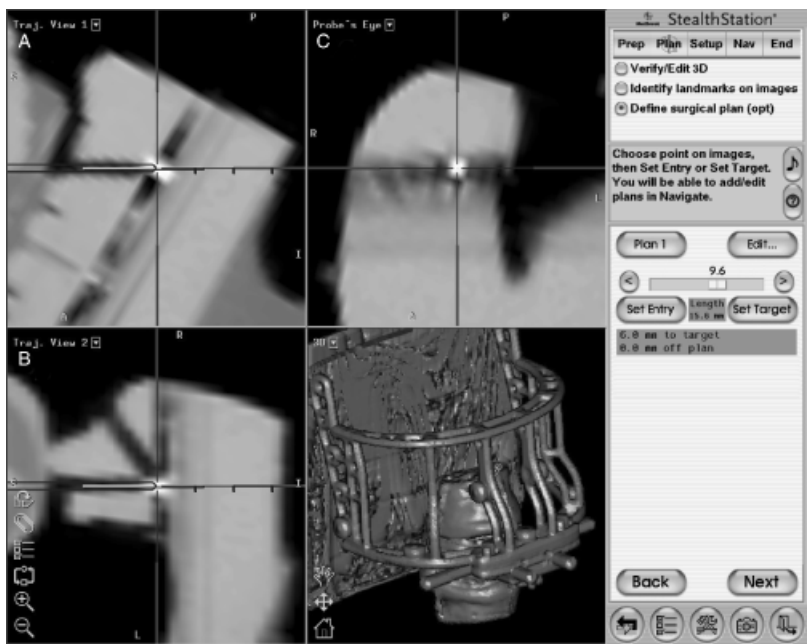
Evaluation of the accuracy on the postoperative computed tomography data. A path with its entry point in the centre of the proximal part of the drill hole and the target point in the centre of the distal part of the drill hole was determined. The path was virtually elongated until the centre of the target was visible on the 'probe's eye view'. The 'probe's eye view' is the perpendicular plane to the path on a given point. There are two longitudinal views along the path (trajectory view 1 – A and 2 – B) and one perpendicular view that allow following the path by the view of the probe (C). The accuracy in the xy-axis (= normal deviation from the virtually elongated drill hole axis) could be evaluated in this plane. This corresponds to the distance with which the drill would have passed the target.
